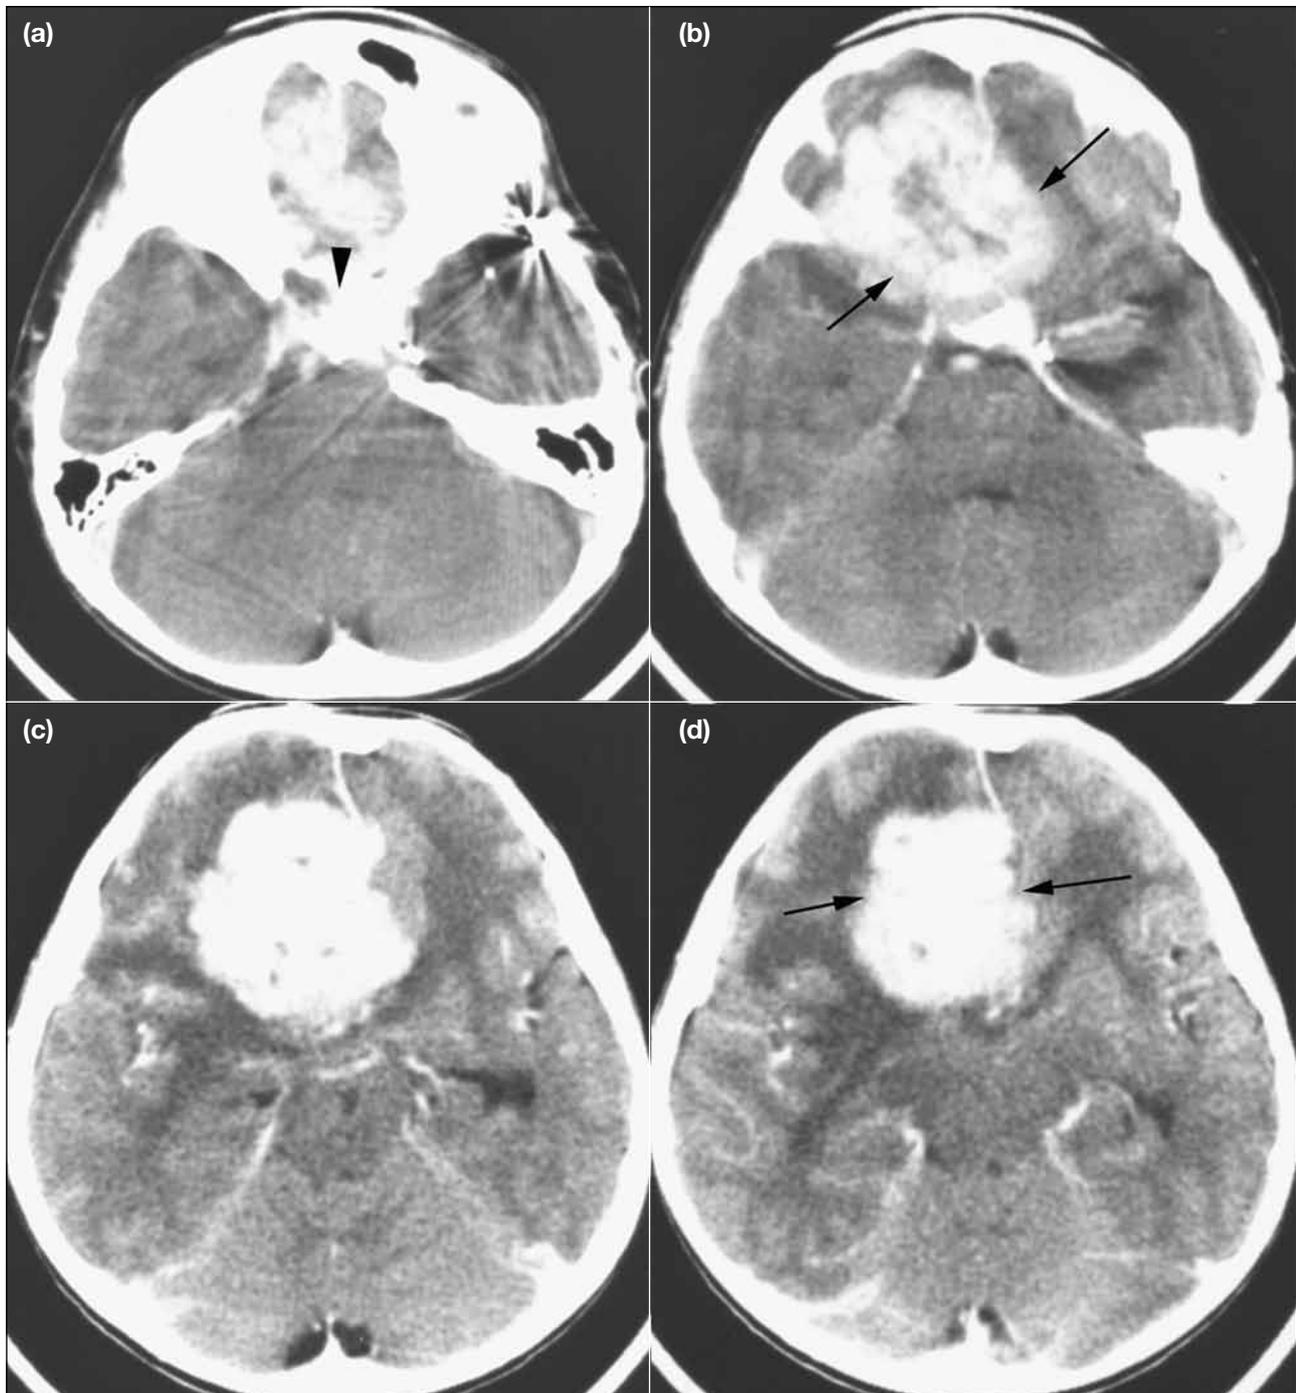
A series of axial computed tomographic scans from the level of the sphenoid wing to the level of the low lateral ventricles shows the tumour's origin at the anterior and mid skull base (arrows in b). The large lobulated enhancing mass with surrounding white matter oedema is most distinctive in (c). The tumour has effaced the lower part of right anterior horn (arrows in d). There is abnormal enhancement of the tuberculum sellae (arrowhead in a).
